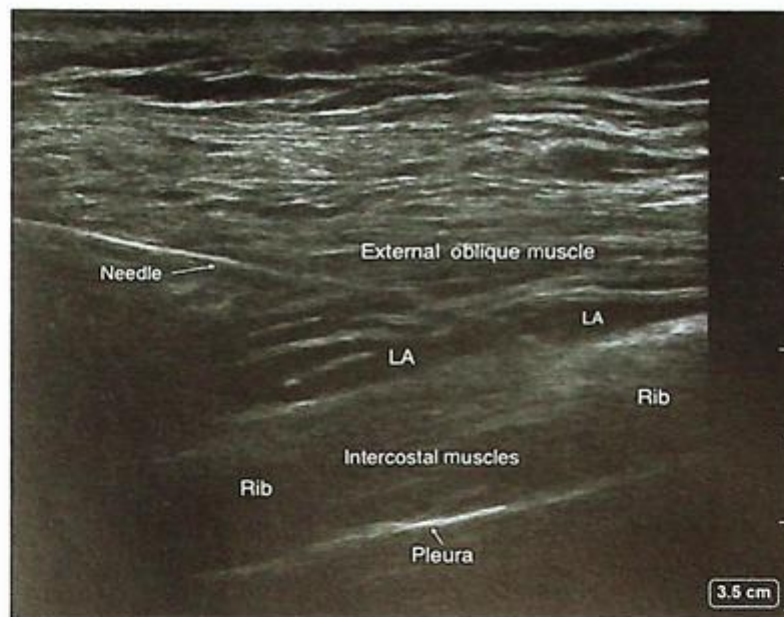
Sagittal ultrasound image of the external oblique intercostal block showing the needle tip on rib 6 elevating the external oblique muscle off the rib and intercostal muscles with local anesthetic (LA) injection.
